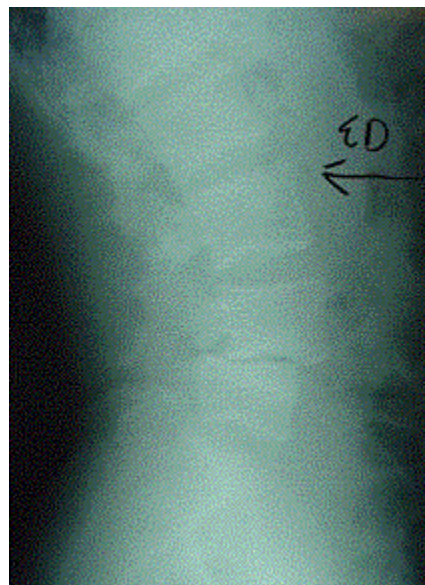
Extension (a) and Flexion (b) radiographs showing increased angulation and instability at L4-5.
